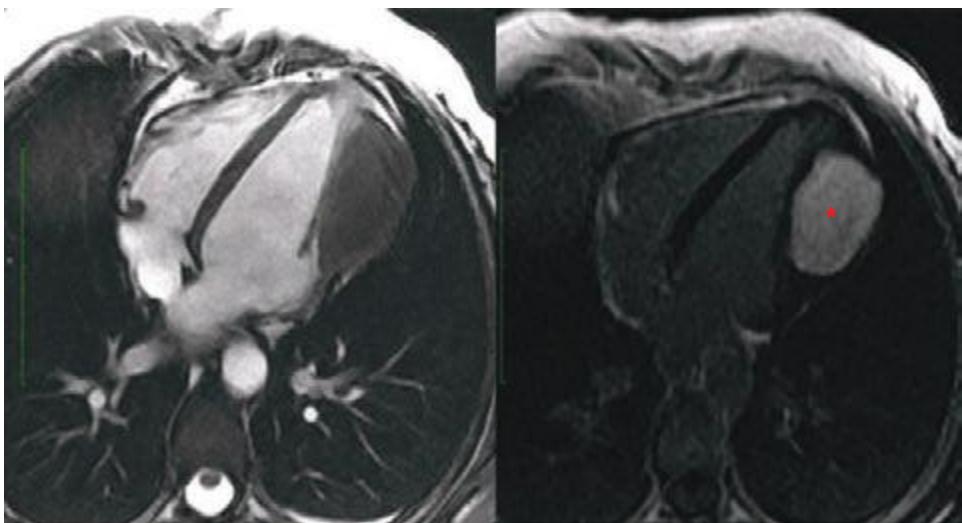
34 A case of a cardiac fibroma. A patient presented with shortness of breath and was found to have a large myocardial mass on echocardiography. Cine cardiac magnetic resonance imaging confirmed the large myocardial mass involving the anterolateral wall. Shortly after gadolinium contrast was injected, the myocardial mass demonstrated intense accumulation of contrast on LGE imaging (right panel, asterisk). This is a case of cardiac fibroma. The patient also has gingival hyperplasia and bifid thoracic ribs, a part of the rare Gorlin's syndrome.
